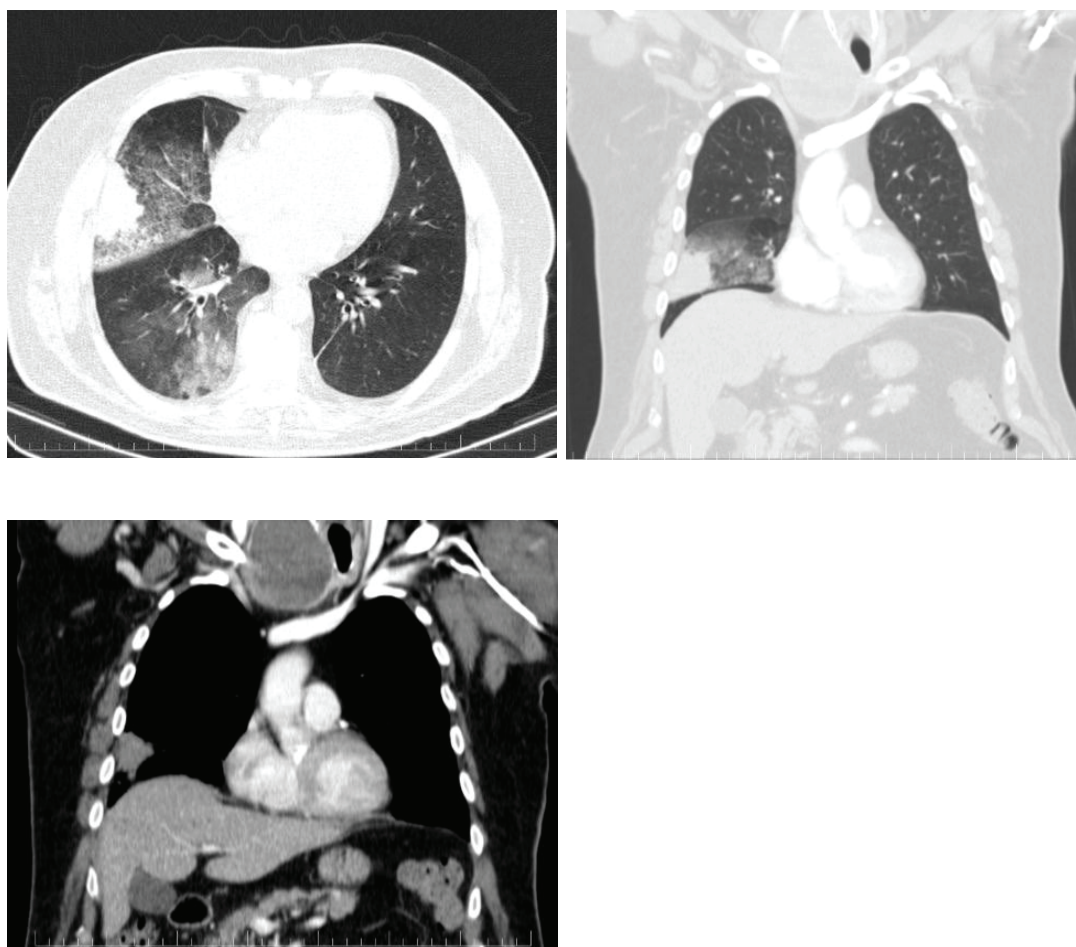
Chest computed tomography: pulmonary condensation of the middle lobe, surrounded with ground glass opacity both at the middle lobe and right lower lobe.
